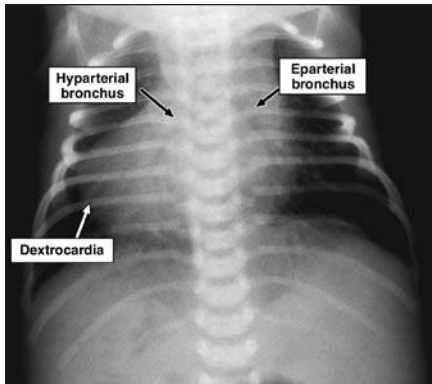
5-day-old boy with dyspnea. Posteroanterior chest radiograph shows situs solitus totalis with dextrocardia, which is associated with congenital heart disease in 3–5% of patients. Note cardiomegaly and pulmonary overcirculation in this patient with single ventricle.
